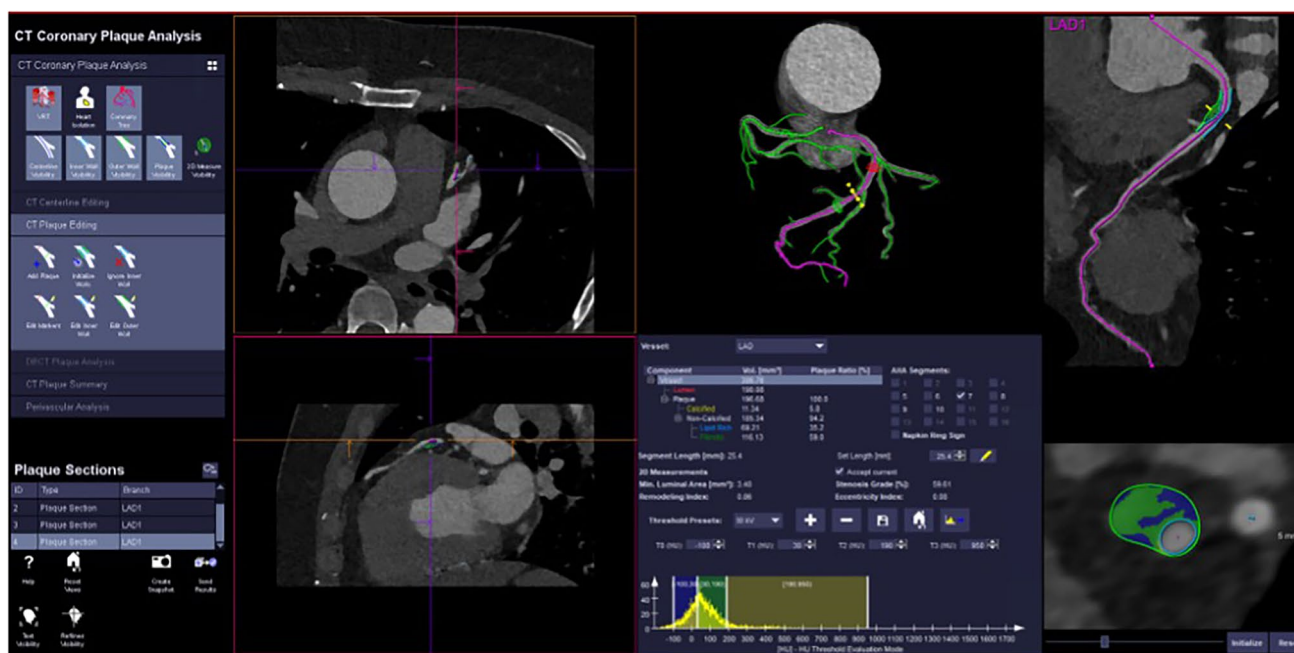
Photon-counting computed tomography: 59.61% stenosis of proximal LAD with a lipid volume of 69.2 mm³, correlated to 35.2% of lipid core burden
